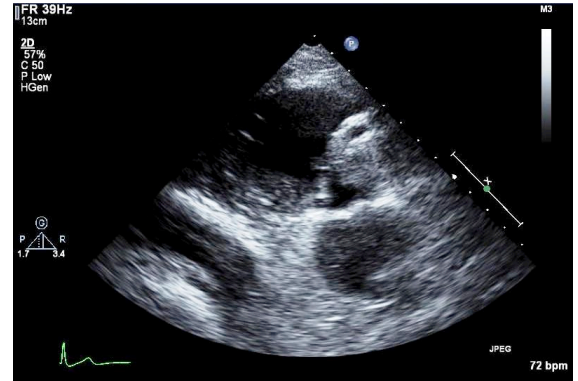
(a) Transthoracic echocardiography, short axis view, demonstrating ectatic right and left coronary arteries (maximum diameter of the ectatic segments 7 mm and 9.4 mm, respectively).
